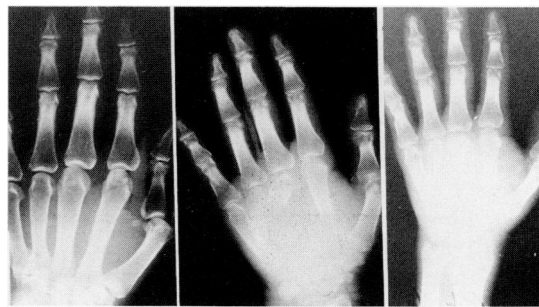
X-ray of the right hand showing essentially normal bony structures (left). X-ray of the right hand shown in Fig. 1 after 3 months interval showing marked destruction of the metacarpal bones (middle). X-ray of the right hand shown in Fig. 2 after irradiation 3000 rads on Co⁶⁰ showing irregular bone formation (right).
